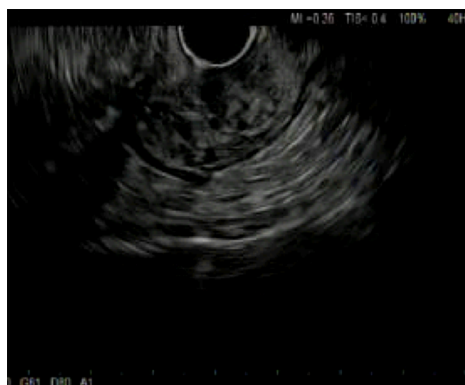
Findings with endoscopic ultrasound. A 2.8 cm × 15.2 cm avascular lesion of mixed echogenicity seen in the submucosa with no communication with muscularis mucosa or propria.
